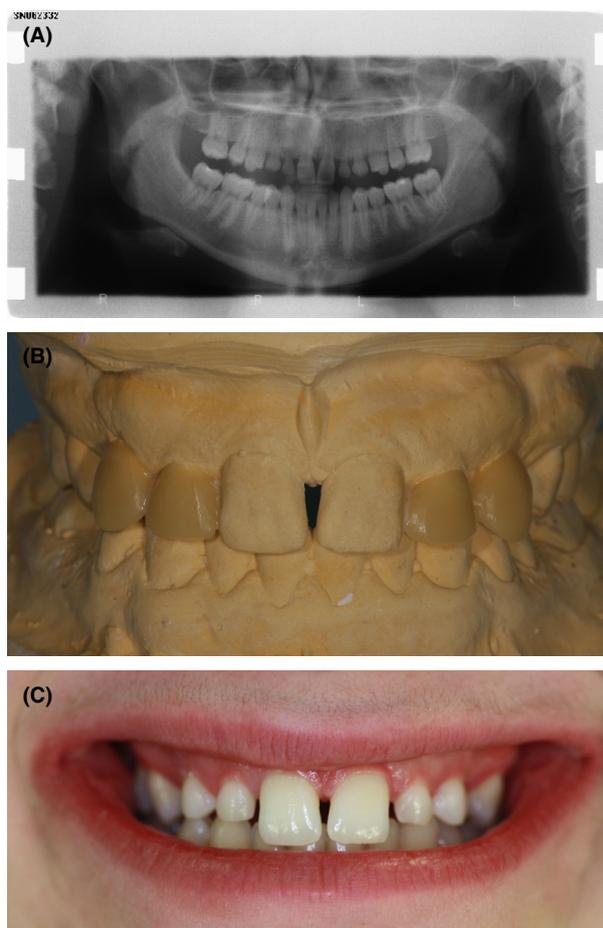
(A) Orthopantomogram showing the retained deciduous teeth with missing permanent successors. Note also the extent of the deciduous root resorption. (B) Anterior view of the diagnostic wax-up, (C) Pretreatment intraoral anterior view photograph.
